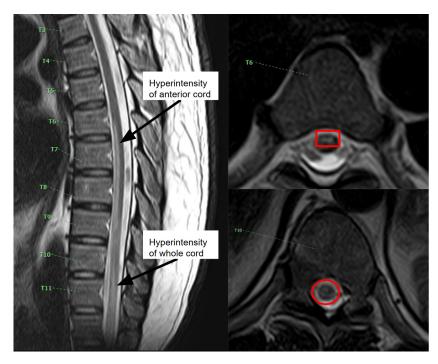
Clockwise from left*. T2-weighted MRI of thoracic spine demonstrating hyperintensity of anterior cord from T6 to T10 level, along with hyperintensity of entire cord below T10 level; corresponding axial image at T6 level demonstrating owl-eyes sign (red box); corresponding axial image at T10 level demonstrating hyperintensity of entire cord (red circle)
